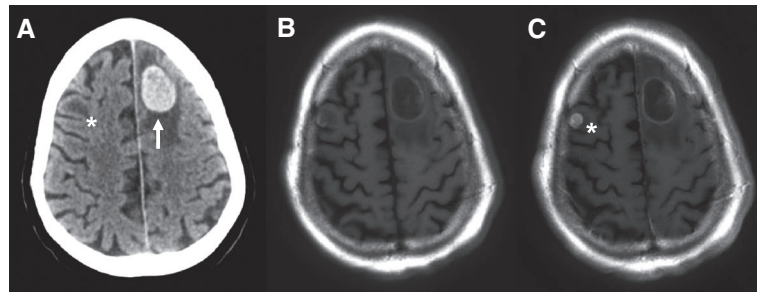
Hemorrhagic metastasis. (A) A noncontrast head computed tomography scan reveals a hyperdense, acute hemorrhage in the left frontal lobe with surrounding hypodensity representing edema (solid arrow). There is also hypodensity in the right frontal lobe suggestive of a second, nonhemorrhagic lesion (asterisk). (B) Pregadolinium T1-weighted sequences show a cystic-appearing lesion in the left frontal lobe that is T1-hypointense; it represents an acute intralesional hemorrhage. (C) Postgadolinium T1-weighted sequences reveal minimal enhancement around the hemorrhagic left frontal lesion and confirm an enhancing lesion in the right frontal lobe (asterisk). Resection of the hemorrhagic left frontal lesion revealed metastatic melanoma.
